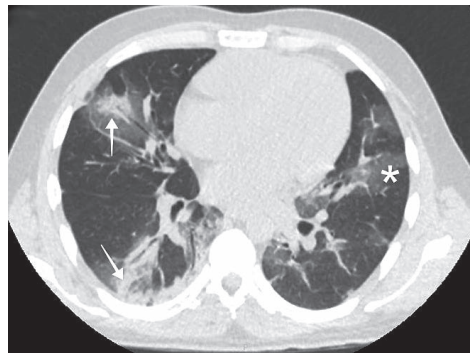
Patient 2: Chest computed tomography on Ct (cycle threshold) nadir (13.8), on 30th day since symptom onset. Remarkable progression of lung ground-glass opacities (asterisk), with areas of parenchymatous consolidation (white arrows). The patient required oxygen through a non-rebreather mask.
